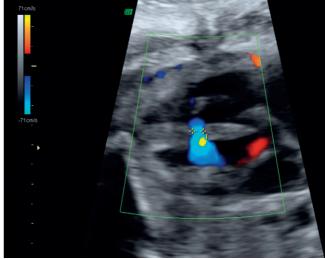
Color Doppler images of ventricular septal defects located in mid-muscular septum, showing bidirectional flow across defect. Note that size of defect may vary slightly between systole and diastole; in the present study the greater diameter was always chosen to evaluate the size of the defect.
